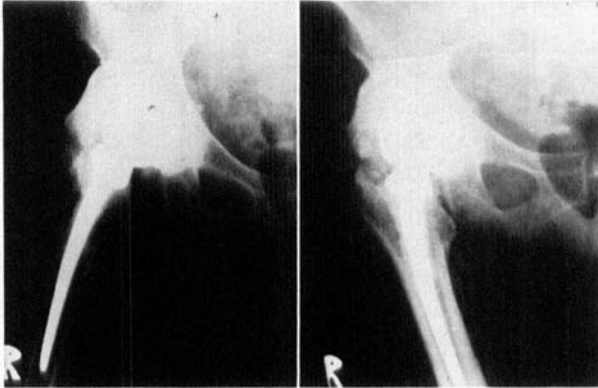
Abduction and adduction radiographs.
